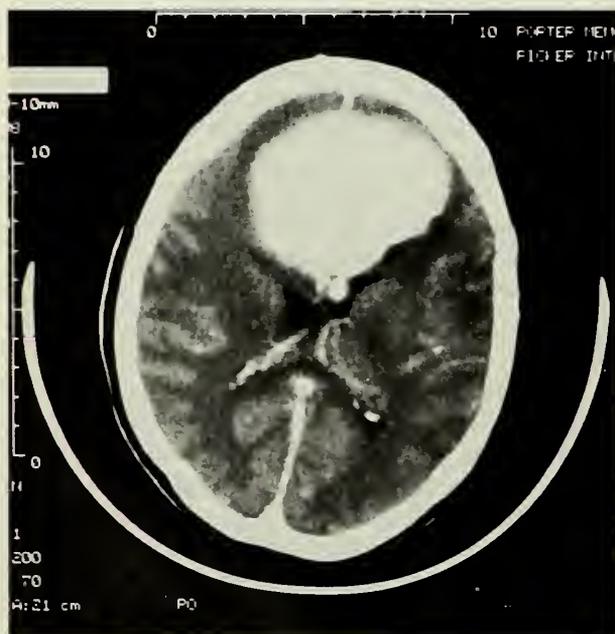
Frontal lobe tumor. Patient 1 had abulia due to a benign meningioma. A computed tomographic scan shows severe compromise of both medial frontal lobes. Note the homogeneous enhancement in the 8-cm mass.
